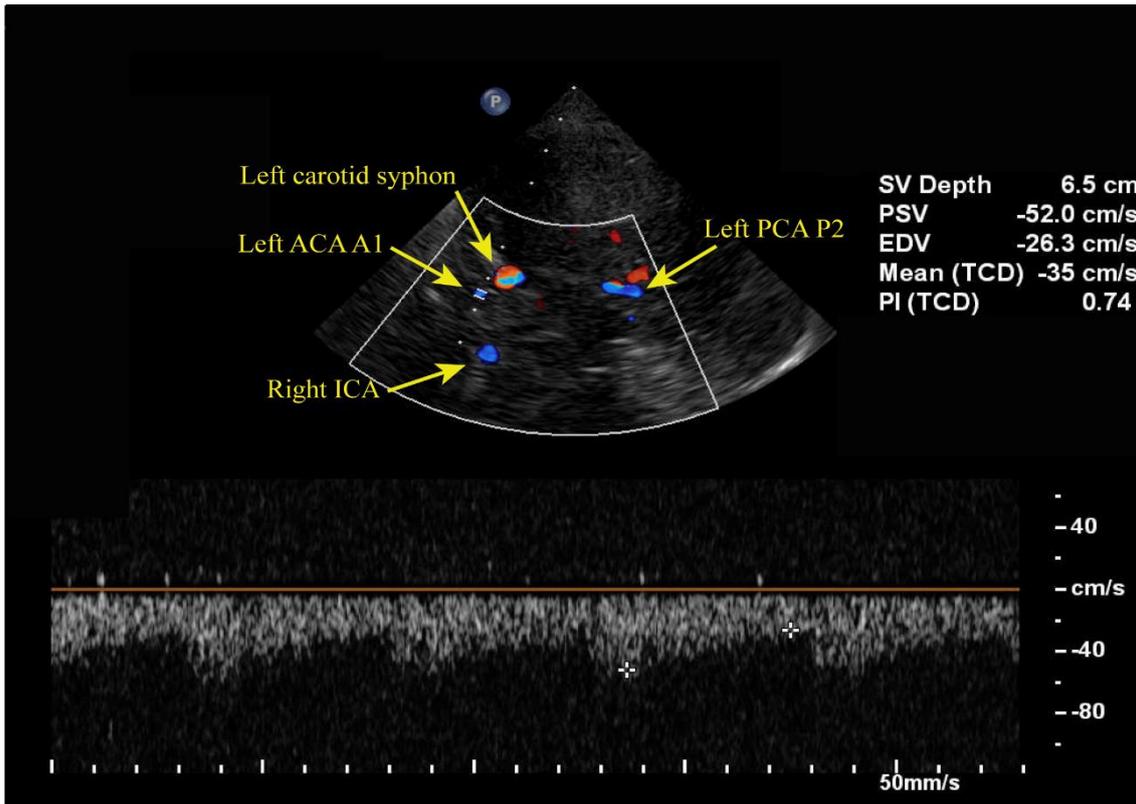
TCCS showing normal flow velocities in the left ACA. ACA: anterior cerebral artery, EDV: end-diastolic velocity, ICA: internal carotid artery, mean (TCD): mean flow velocity, PCA: posterior cerebral artery, PI (TCD): pulsatility index, PSV: peak systolic velocity, SV depth: sample volume depth, TCCS: transcranial color-coded duplex sonography. Courtesy of Dr. Zsolt Garami.
